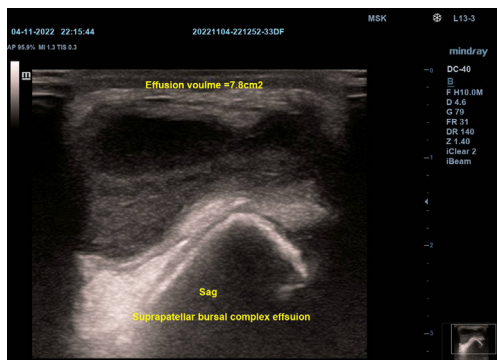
Knee ultrasound, sagittal scan. Enlargement of the hypoechoic area in the joint capsule, indicating fluid retention (suprapatellar bursal complex joint effusion).
